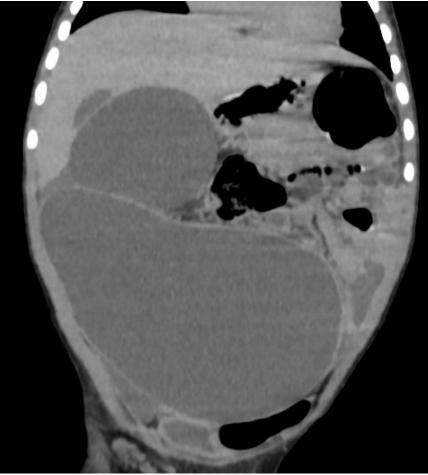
a and 4b-Follow up computed tomography image coronal and sagittal sections demonstrating the extent of the cyst.
